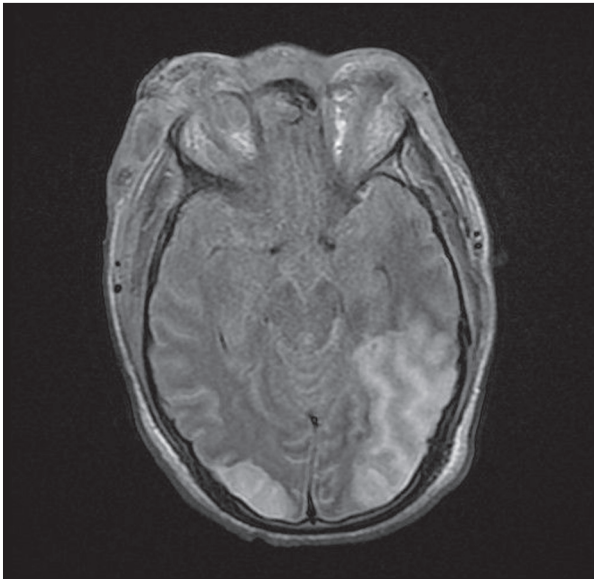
T1 Flair magnetic resonance imaging showing bilateral occipital hypersignal in relation with venous infarction.
